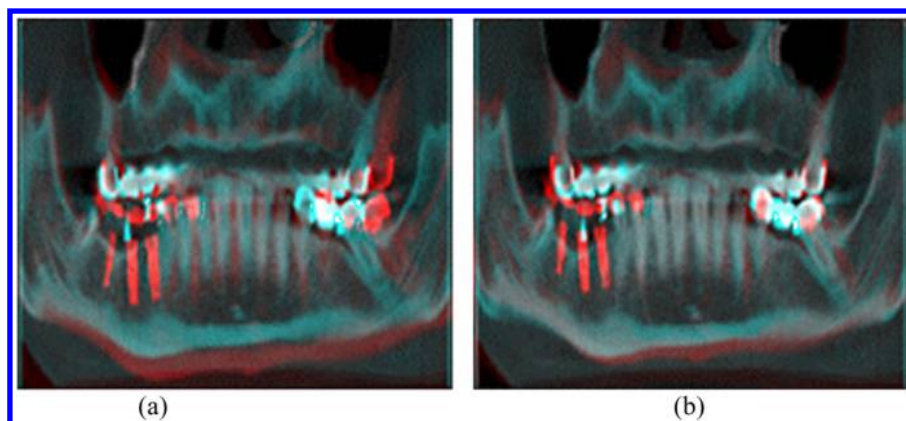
Example of comparing panoramic images reconstructed from (a) misaligned and (b) aligned preoperative and postoperative CBCT volumes. Misalignment errors are visible as ghosting artefacts in lower and right hand side sections of (a) (In the online version a red color tone corresponds to information present only in the postoperative and cyan to information present exclusively in the preoperative panoramic image).
